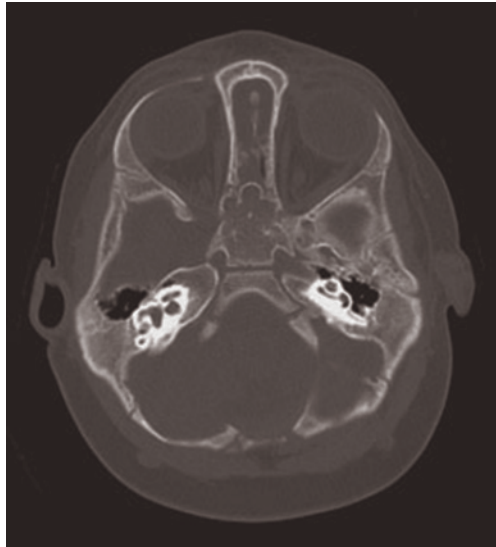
Axial CT scan. Hypoplasia of the middle and posterior fossa on the left side in patient with left microtia and atresia.
